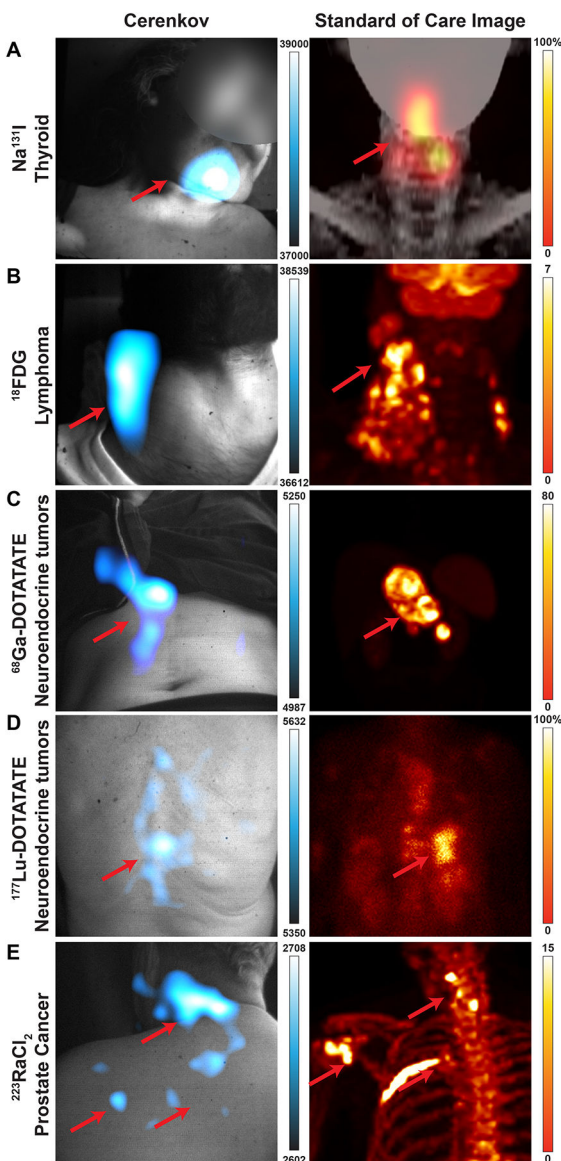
Representative patients by isotope for fiberscope Cerenkov luminescence imaging. Cerenkov luminescence images of the patients (left) compared to their standard-of-care PET or SPECT/planar scan (right). Brightest Cerenkov luminescence imaging regions align with the most avid regions. As Cerenkov luminescence imaging is optical, avid lesions overlaid by tissue will appear dimmer than similarly avid lesions closer to the surface.
